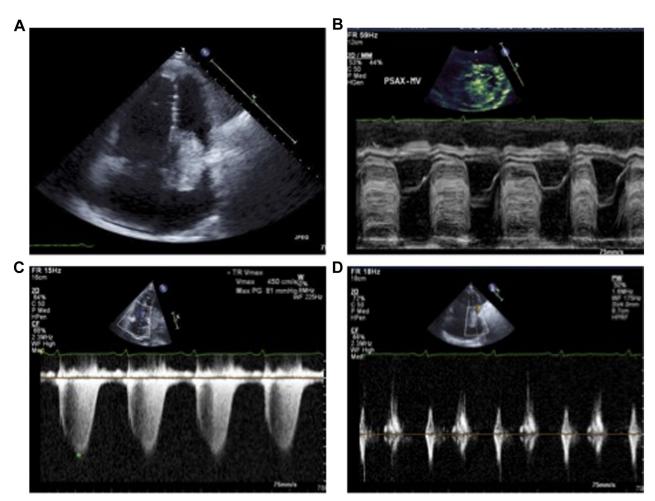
(A) Apical four-chamber view of left atrial mass; (B) M mode of left atrial mass; (C) mitral valve inflow obstruction due to left atrial mass; and (D) severe pulmonary hypertension due to left atrial mass.
